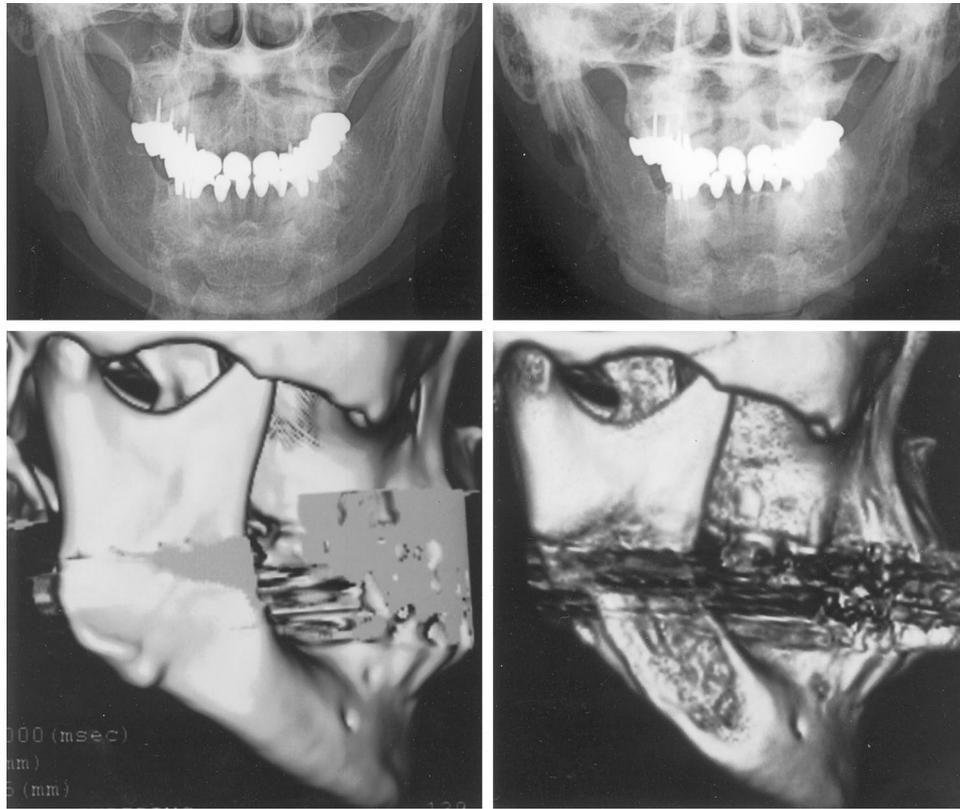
The patient in case 1, a 55-year-old woman. (Above, left) Preoperative frontal cephalogram shows remarkable lateral flaring of the mandibular angle. (Above, right) Postostectomy cephalogram. (Below, left) Preoperative three-dimensional computed tomographic scan. (Below, right) Postostectomy three-dimensional computed tomographic scan reveals a successful reduction of the angle.
